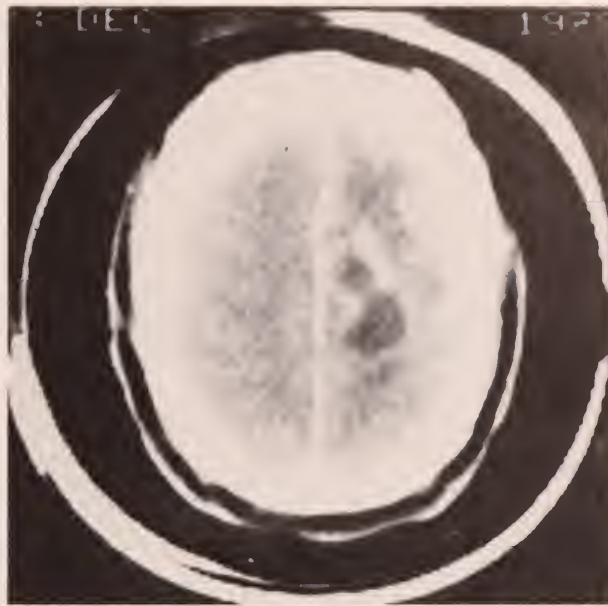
This patient had a multilocular abscess with variable wall thickness. This case demonstrates the variability of appearance of abscess on CT scans. Such multilocular lesions may be difficult to distinguish from malignant cerebral neoplasms by scan pattern alone.
